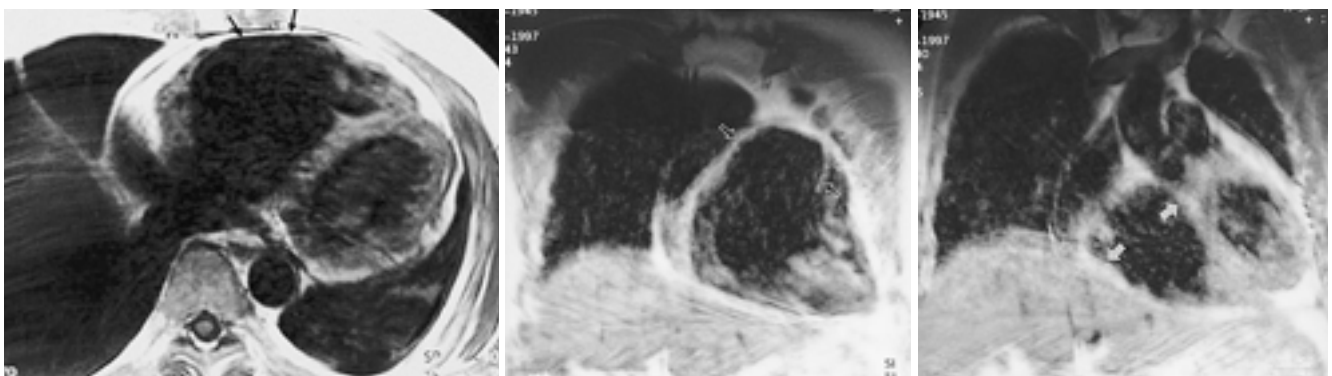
T1-weighted MR imaging of a 53-year-old man who presented with a sudden cardiac arrest (case 13). A. Axial MR image obtained at the midventricular level shows myocardial wall thinning at the right ventricular free wall (arrows) and also there is global right ventricular dilatation. The interventricular septum shows convexity to the left ventricular side. B, C. Coronal MR images show aneurysmal dilatation of the right ventricular outflow tract (open arrows in B). Right ventricle is dilated globally (arrows in C).
